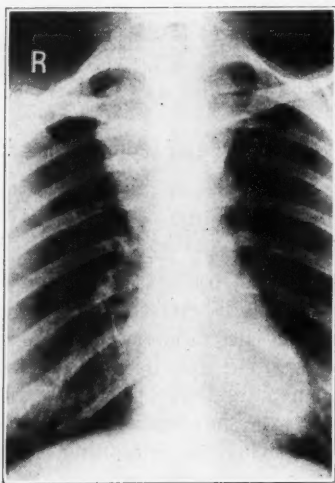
Roentgenogram of the chest showing the mediastinal tumor.
